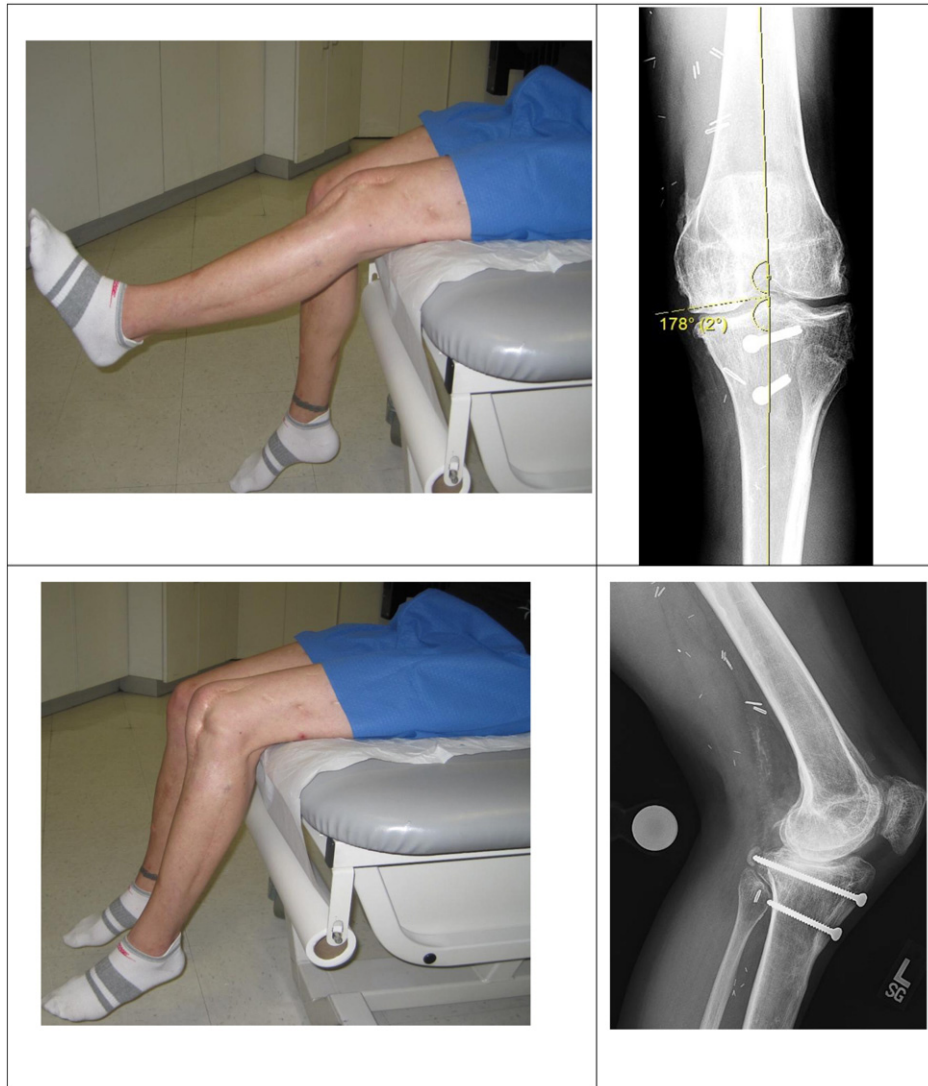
Recent clinical photographs and weight bearing radiographs of the knee (December 2013, seven years from the latest surgery) showing good knee ROM and varus tibiofemoral angle of 2°.
